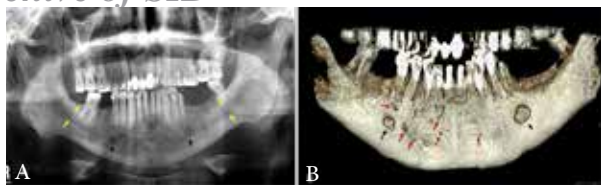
A Panoramic radiograph showing wide mental foramina bilaterally (black arrows) with mild enlargement of the mandibular canals bilaterally (yellow arrows) and no significant widening of the mandibular foramina (mf). B Panoramic reconstruction of the CBCT scan showing multiple accessory mental foramina (red arrows) on the right side and isolated accessory mental foramen on left side and wide mental foramina bilaterally (black arrows).
